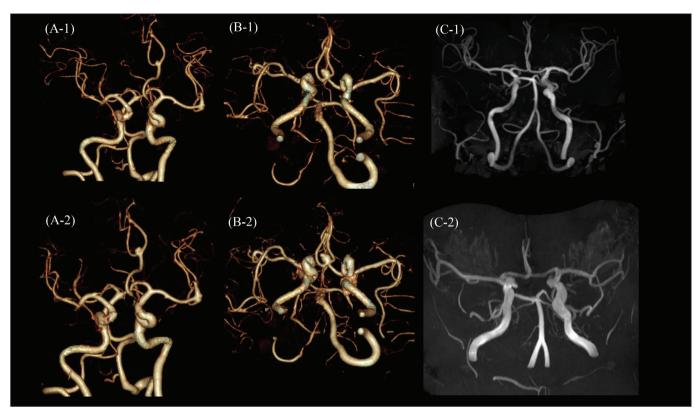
Three cases of aneurysm growth in octogenarian patients with unruptured intracranial aneurysm (A-1, A-2) Case of an 81-year-old female patient with a distal anterior cerebral artery (ACA) aneurysm in the azygos ACA. (A-1) Initial brain computed tomography angiography (CTA) showing a 2 mm aneurysm in the distal ACA. (A-2) Annual brain CTA image at the 2-year follow-up, revealing aneurysm growth (from 2 to 4 mm). The patient underwent clipping surgery. (B-1, B-2) Case of an 80-year-old male patient with an anterior communicating artery (AcomA) aneurysm. (B-1) Brain CTA revealing a 6 mm AcomA aneurysm. (B-2) Patient opted for conservative management. In the 1-year follow-up CTA, aneurysm growth (from 6 to 8 mm) was noted. Treatment was recommended, but the patient refused to proceed with the treatment. (C-1, C-2) Case of an 82-year-old female patient with a right paraclinoid aneurysm. (C-1) Initial brain magnetic resonance angiography showing a 2 mm right paraclinoid aneurysm. (C-2) Conservative management was recommended. Follow-up imaging after 2 years revealed aneurysm growth (from 2 to 4 mm). Coiling was recommended, but the patient refused the treatment.
